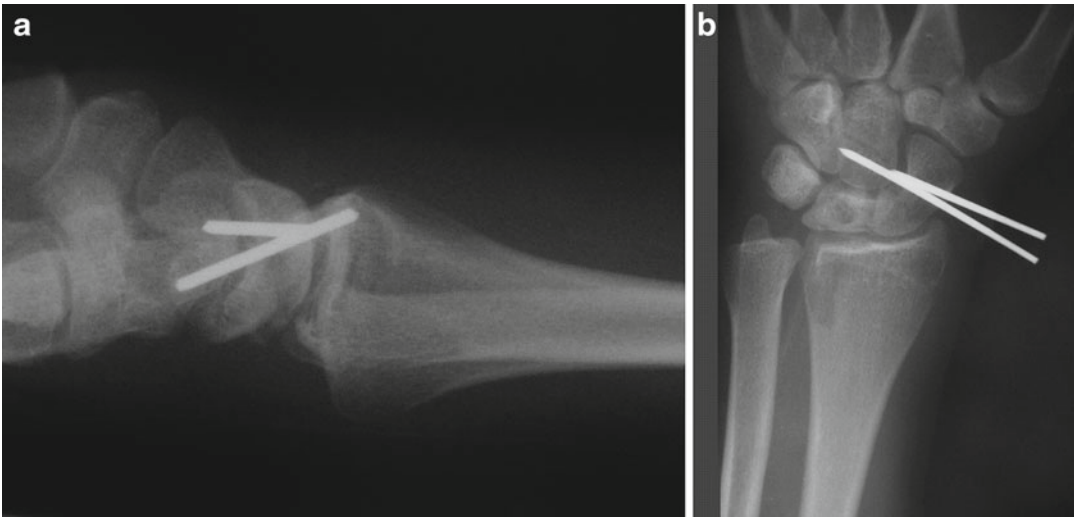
(a) Antero-posterior radiograph depicting temporary unloading of lunate via a scaphocapitate pinning with Kirschner wires. (b) Lateral radiographic depicting
